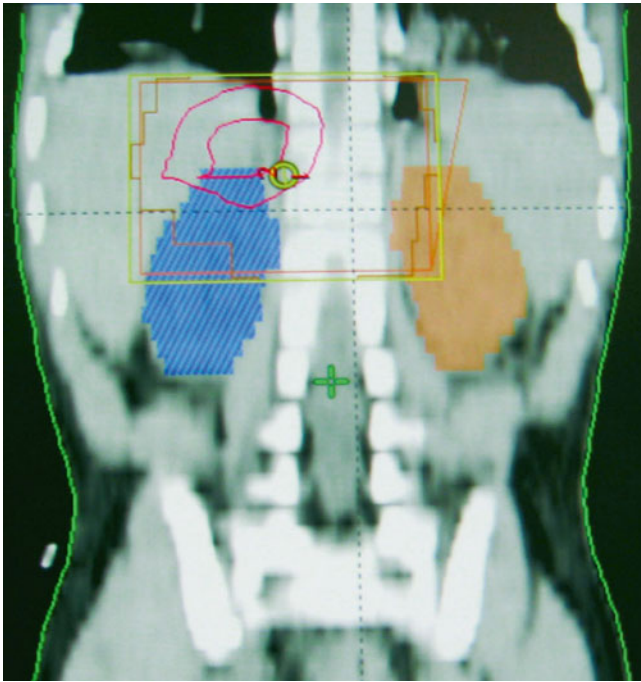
Sagittal reformatted planning CT scan showing position of kidneys, target area (*red*) and edges of the anterior treatment field (*yellow*)
